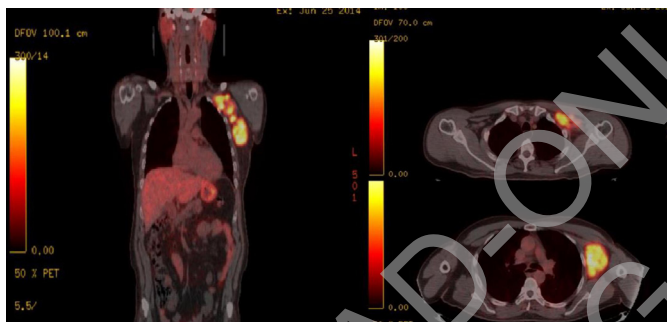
Ga68 PET/CT scan – Pre-operative Baseline scan.
